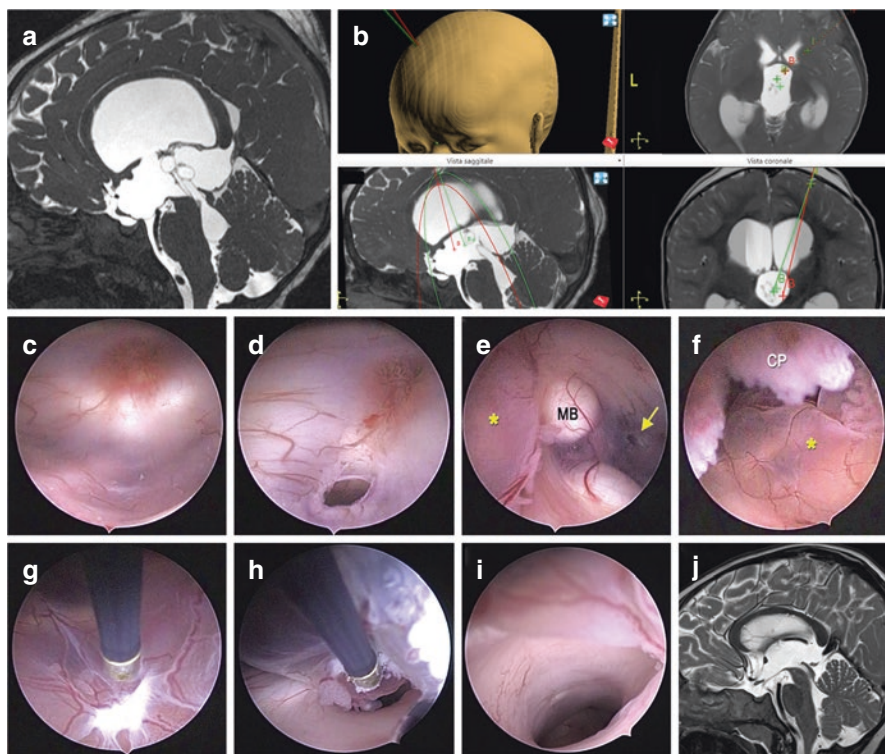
Endoscopic ETV and intraventricular cyst coagulation. (a) Preoperative T2-weight MR sagittal sequence, showing a triventricular hydrocephalus, due to a cyst developing within the third ventricle and occluding the aqueduct of Sylvius; (b) Endoscopic treatment was planned, including ETV (red trajectory) and cyst coagulation (green trajectory); (c, d) Endoscopic view of the third ventricle floor before (c) and after (d) ETV; (e, f) Using robotic neuronavigation, the endoscope is moved from anterior to posterior, according to the second trajectory. The ETV (arrow), the mammillary bodies (MB), the cyst (*), and the choroid plexus (CP) are visualized; (g–i) Coagulation allows progressive shrinking of the cyst (g), until the aqueduct of Sylvius (h) is visualized and free; (j) Postoperative T2-weighted MRI, confirming the hydrocephalus' reduction
